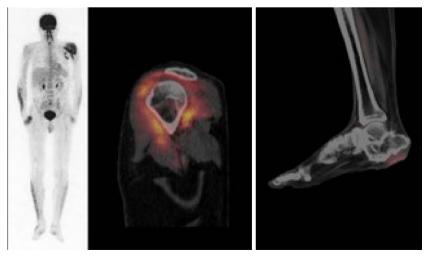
FDG-PET-CT scan of a patient with septic arthritis caused by *Streptococcus zooepidemicus*. Note the high FDG uptake in the left shoulder, as well as an increased uptake in the plantar soft tissue lesion. No other hotspot was observed.
